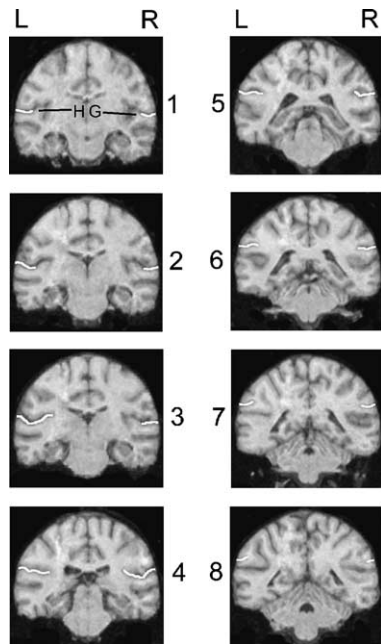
Sequence of coronal MRI slices through the posterior part of the sylvian fissure of a chimpanzee brain. Slice 1 is the most anterior section and slice 8 is the most posterior section of the brain. The extent of the right and left planum temporale in each slice is marked with a white line. L: left; R: right.
